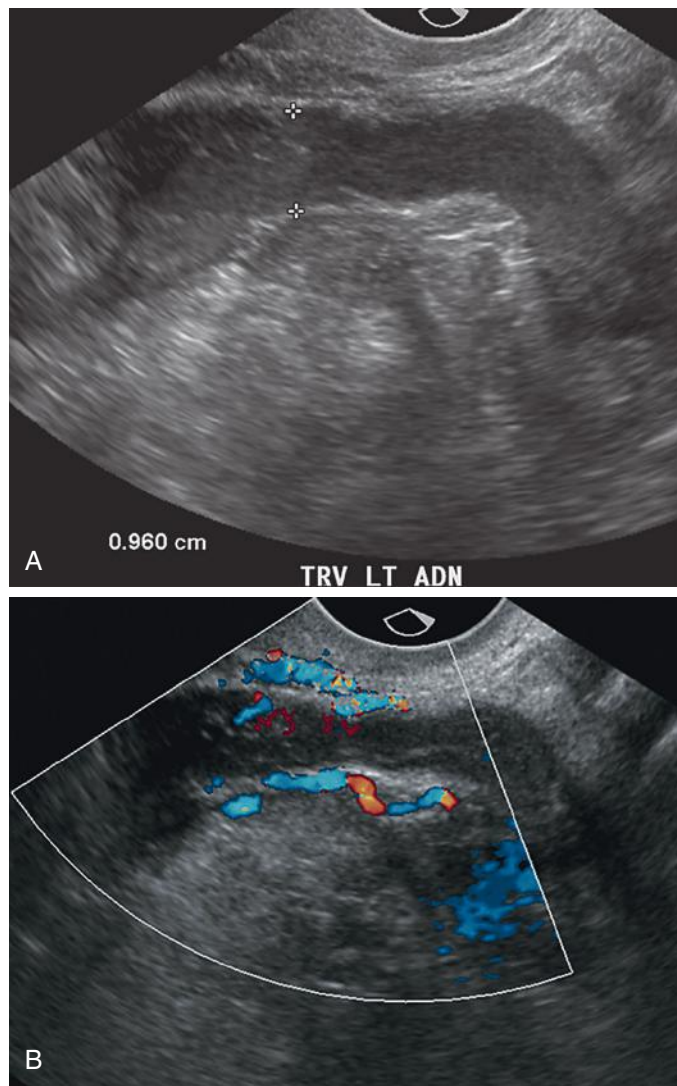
Salpingitis. Note thickened (0.96 cm) left fallopian tube (*calipers*) on gray-scale image (A) in a patient presenting with pelvic pain, fever, and vaginal discharge. Color Doppler image (B) demonstrates increased vascularity in the wall of the tube and in the surrounding inflamed peritubal fat. There is no discernible fluid in the lumen of the tube.
